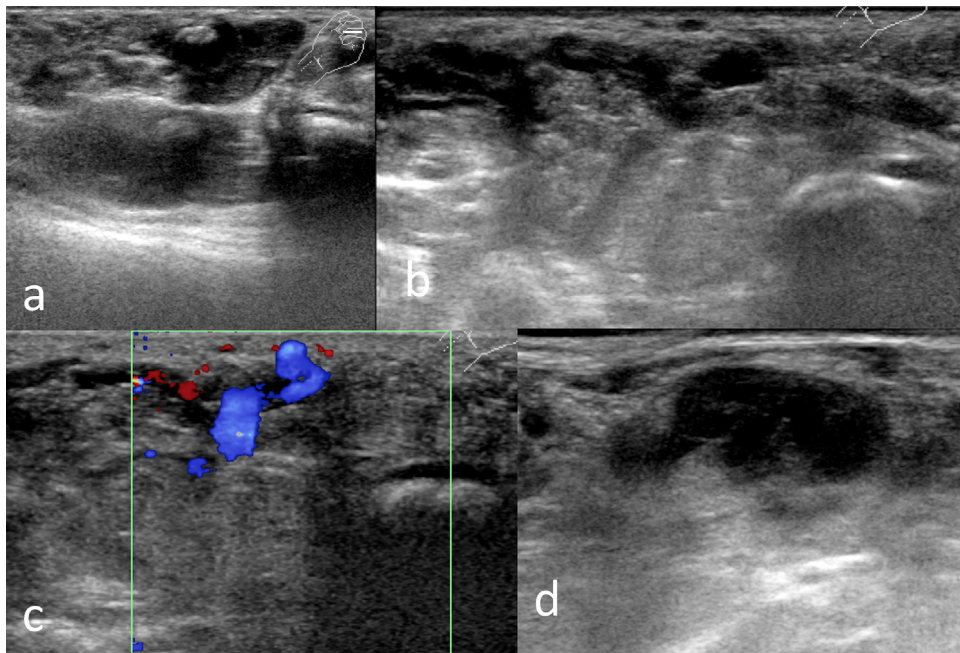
a–d: Ultrasound with a 17 MHz linear array transducer of the left hand of a seven years old patient with a slow-flow venous malformation. Ultrasound displays several malformed dilated hypoechoic venous clusters (Fig. 2a–b) with partial central thrombosis (Fig. 2d), located subcutaneously and epifascial. Slow-flow characteristics on ultrasound (Fig. 2c).
